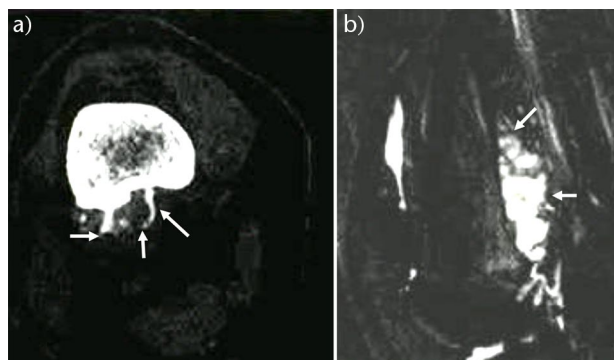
Periosteal osteosarcoma in a 17-year-old female, presenting with a lytic process at the posterior aspect of the right femur as incidental finding. (A) An axial computerized tomography (CT) image shows a soft tissue mass extending from the posterior aspect of the right distal femur. The typical sunray mineralized spicules are seen within the mass. Distal aspect. (B) A sagittal (left) and an axial (right) fat-suppressed T2w magnetic resonance image show a lobulated, hyperintense mass adherent to the posterior aspect of the femur, with mild cortical erosion. The endosteal surface of the cortex and the medullary cavity appear normal.
